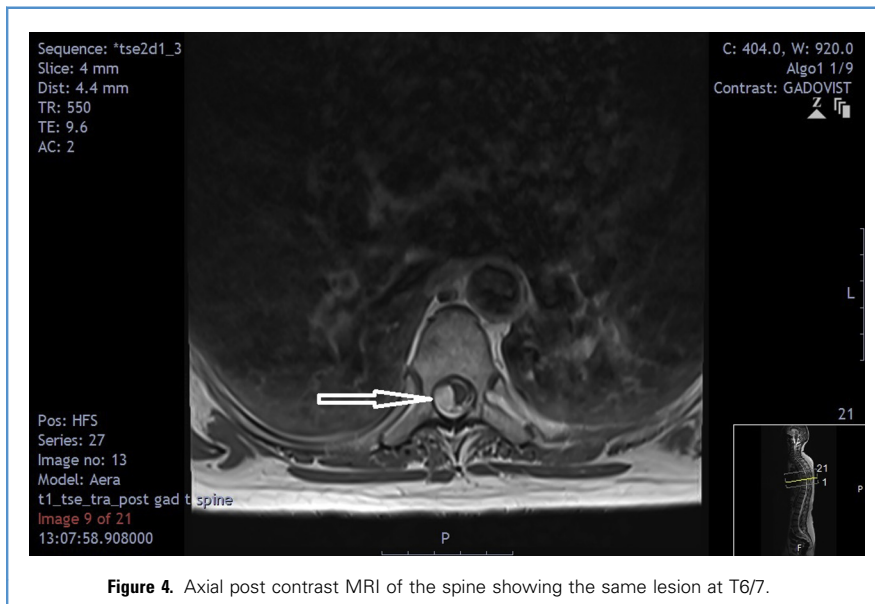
Axial post contrast MRI of the spine showing the same lesion at T6/7.
